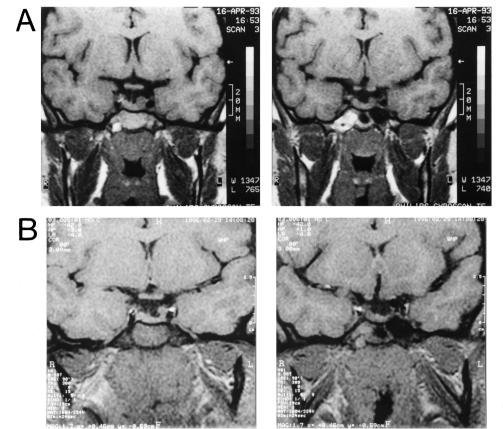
MRI before (A) and after 3 months of CAB treatment (B) in a patient with macroprolactinoma (no. 6, Tables 1–3). Shrinkage was evident in two different coronal sections.
